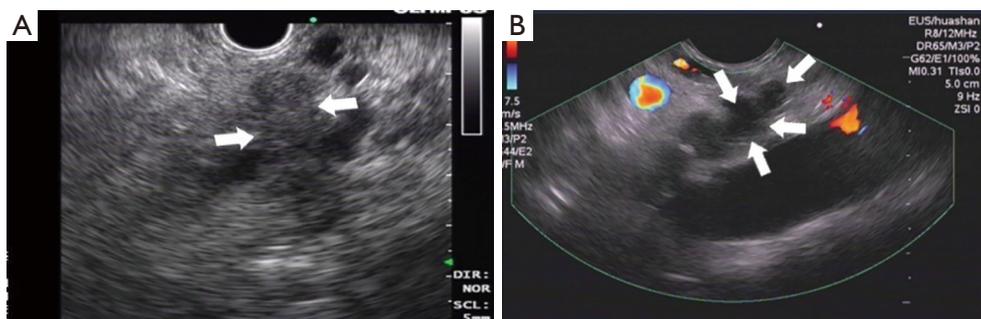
Endoscopic ultrasound (EUS) images show the coagulative necrosis generated after radiofrequency ablation (RFA). (A) EUS images of the pancreatic mass (arrow) before EUS-RFA; (B) EUS images of the ablated area (arrow) after three sessions of EUS-RFA.
